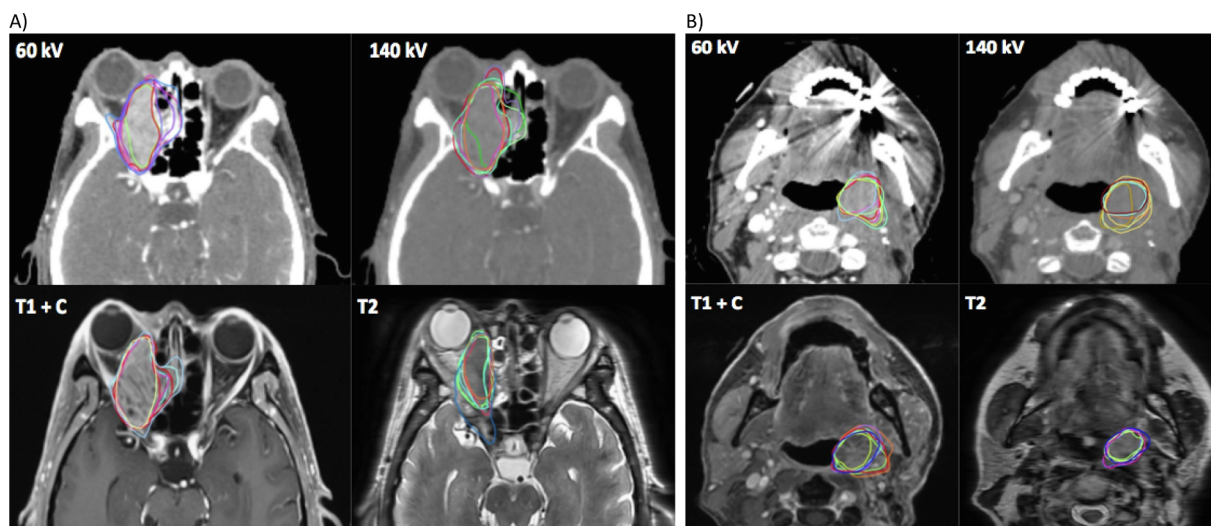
Example of a skull base (A) and a non-skull base (B) cases with delineations on 60 kV, 140 kV, T1 with contrast (T1 + c) and T2 MRI sequences.
